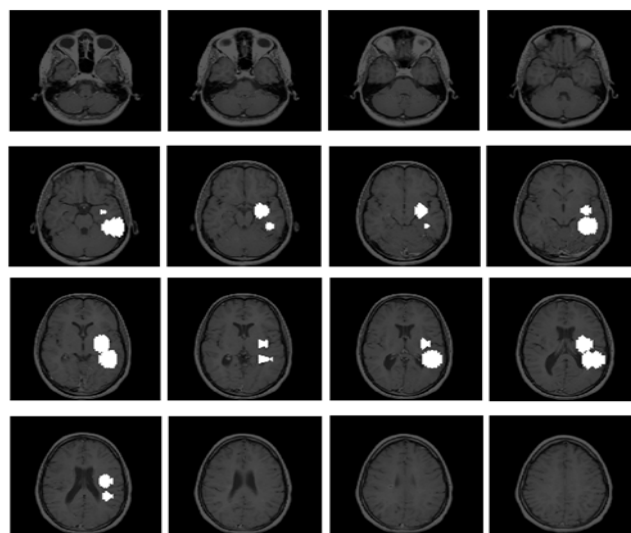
16 MRI slices (out of 27) with glioma in advanced stage. White areas are the tumor areas as delineated by the clinician.
